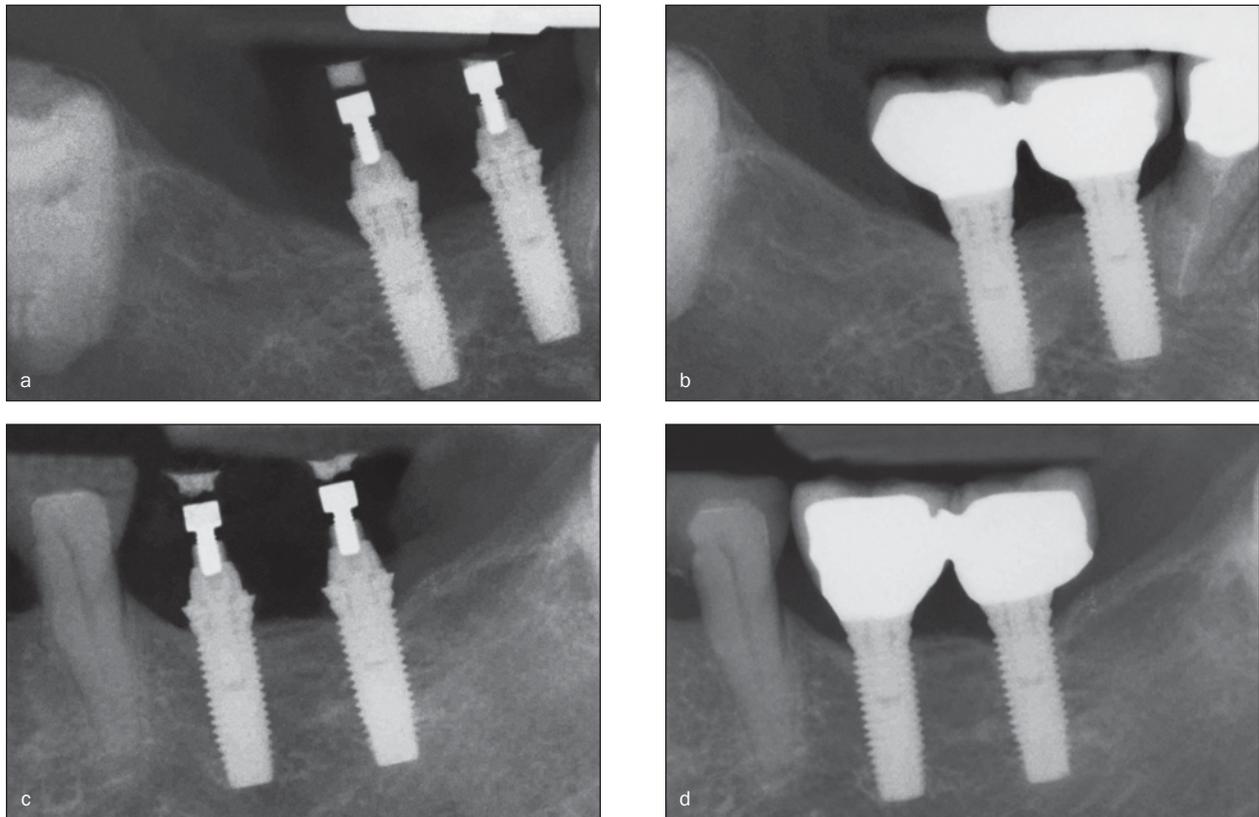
Radiographs of (a) machined implants at baseline, (b) machined implants at 12 months, (c) TiO implants at baseline, and (d) TiO implants at 12 months.
